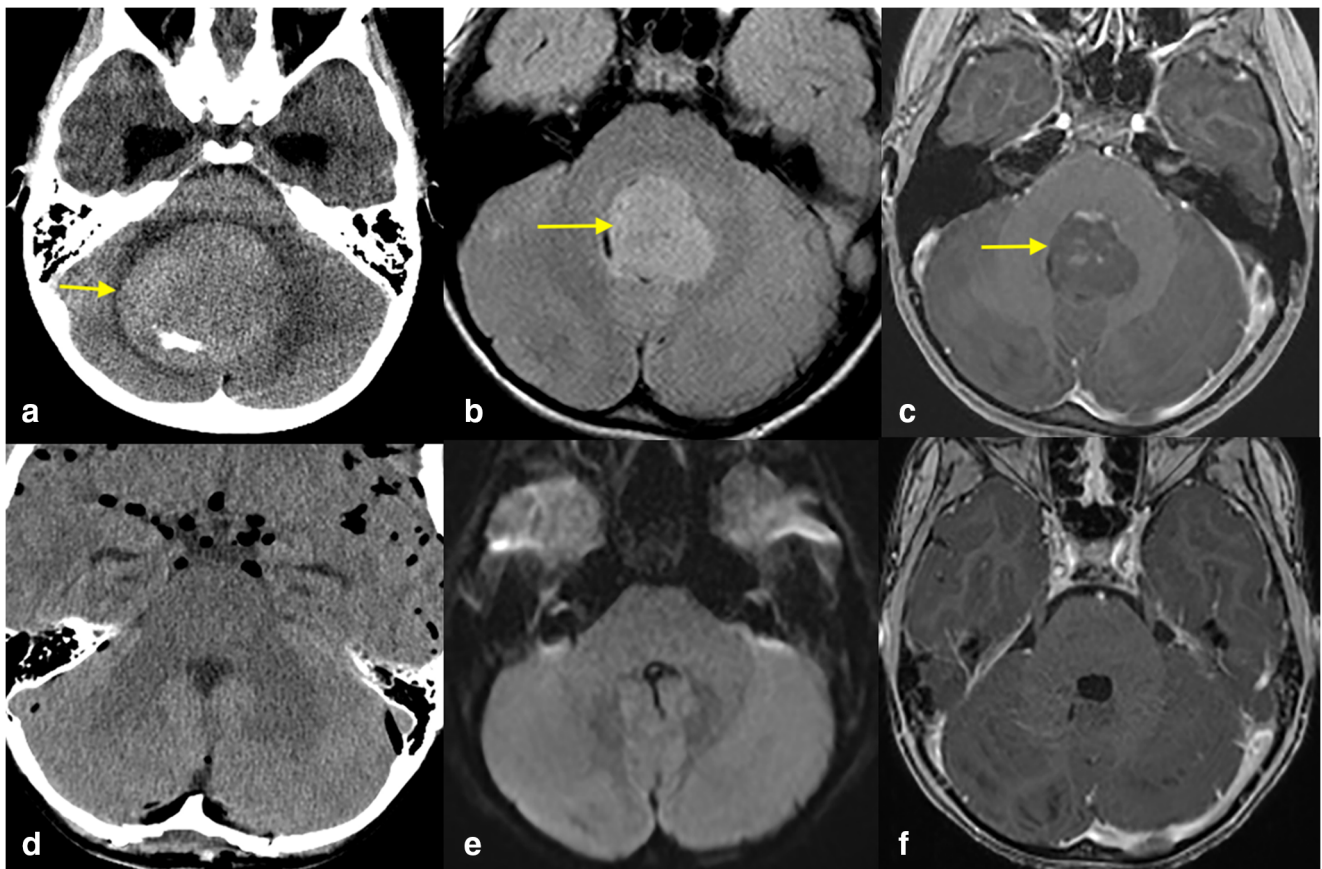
Case 2. Axial CT (a); MRI; FLAIR (b), and post-contrast T1W (c) shows partially calcified and mildly enhancing original tumor in the fourth ventricle (yellow arrows). Post-operative CT (d) shows immediate post-operative findings with post-surgical pneumocephalus and MRI; diffusion-weighted imaging (e) and post-contrast T1W (f) images showing no abnormal diffusion restriction or enhancement to suggest residual tumor
